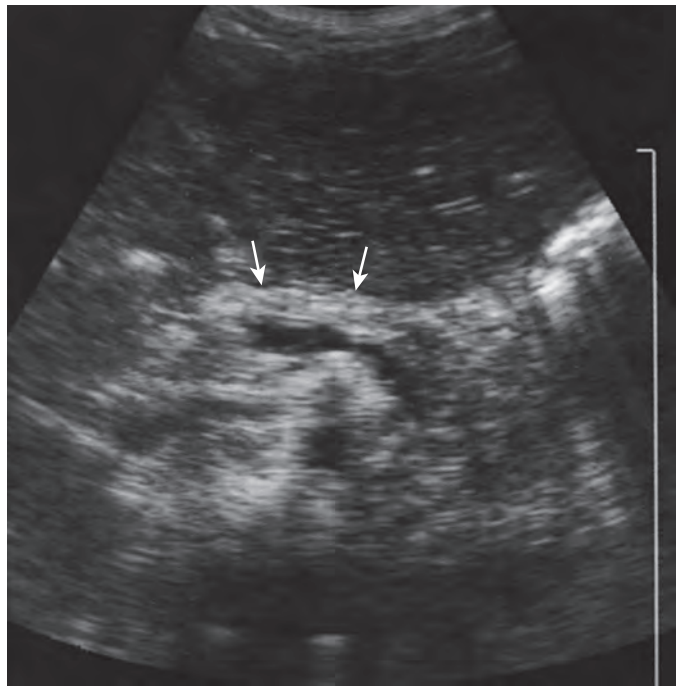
Ultrasound findings of the pancreas in cystic fibrosis. Transverse ultrasound shows the pancreas to be thin and markedly echogenic as a result of atrophy and fat infiltration (arrows) in a 7-year-old boy with cystic fibrosis.
